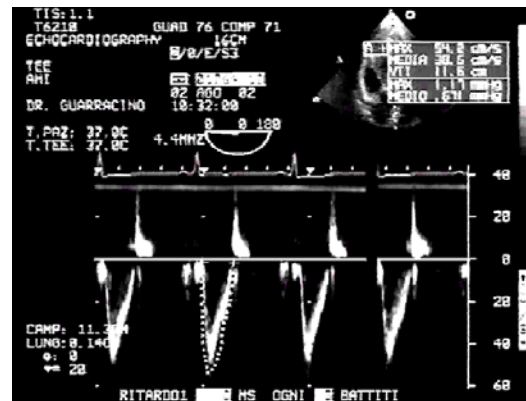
b VTI measurement by Doppler
